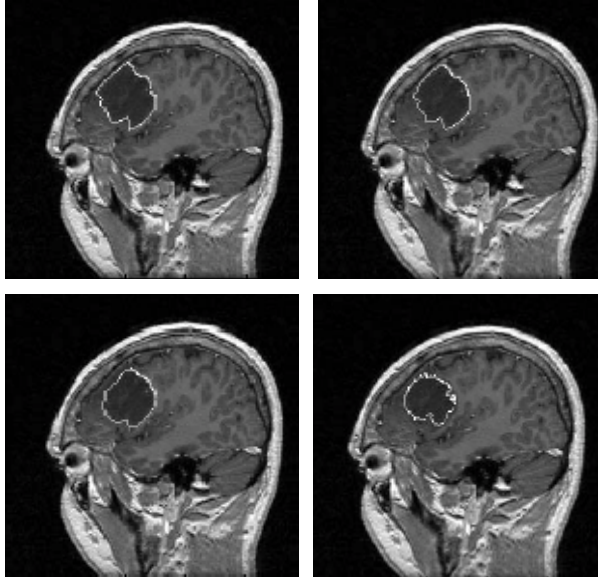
Manual segmentation by four different experts of a glioma on the MRI [Luo 2003].
